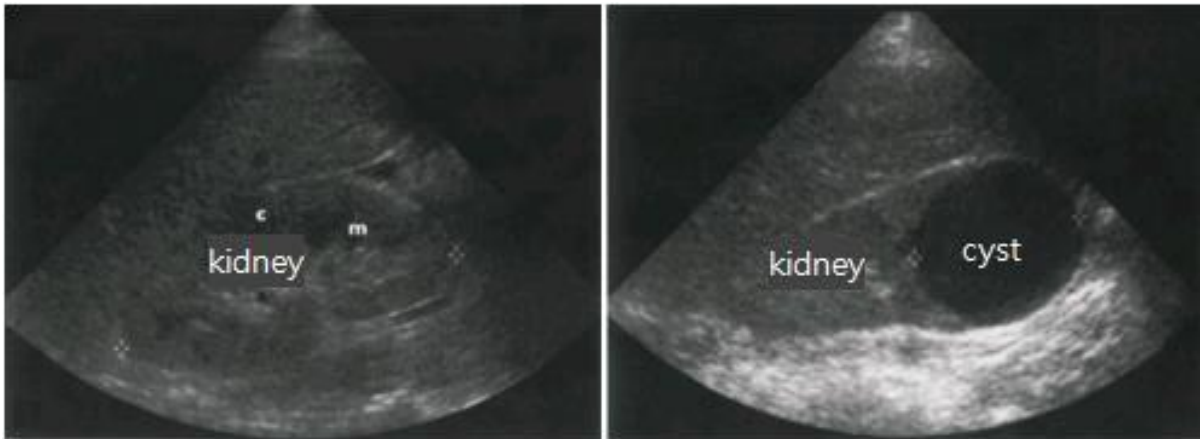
Kidney cyst image using ultrasound
